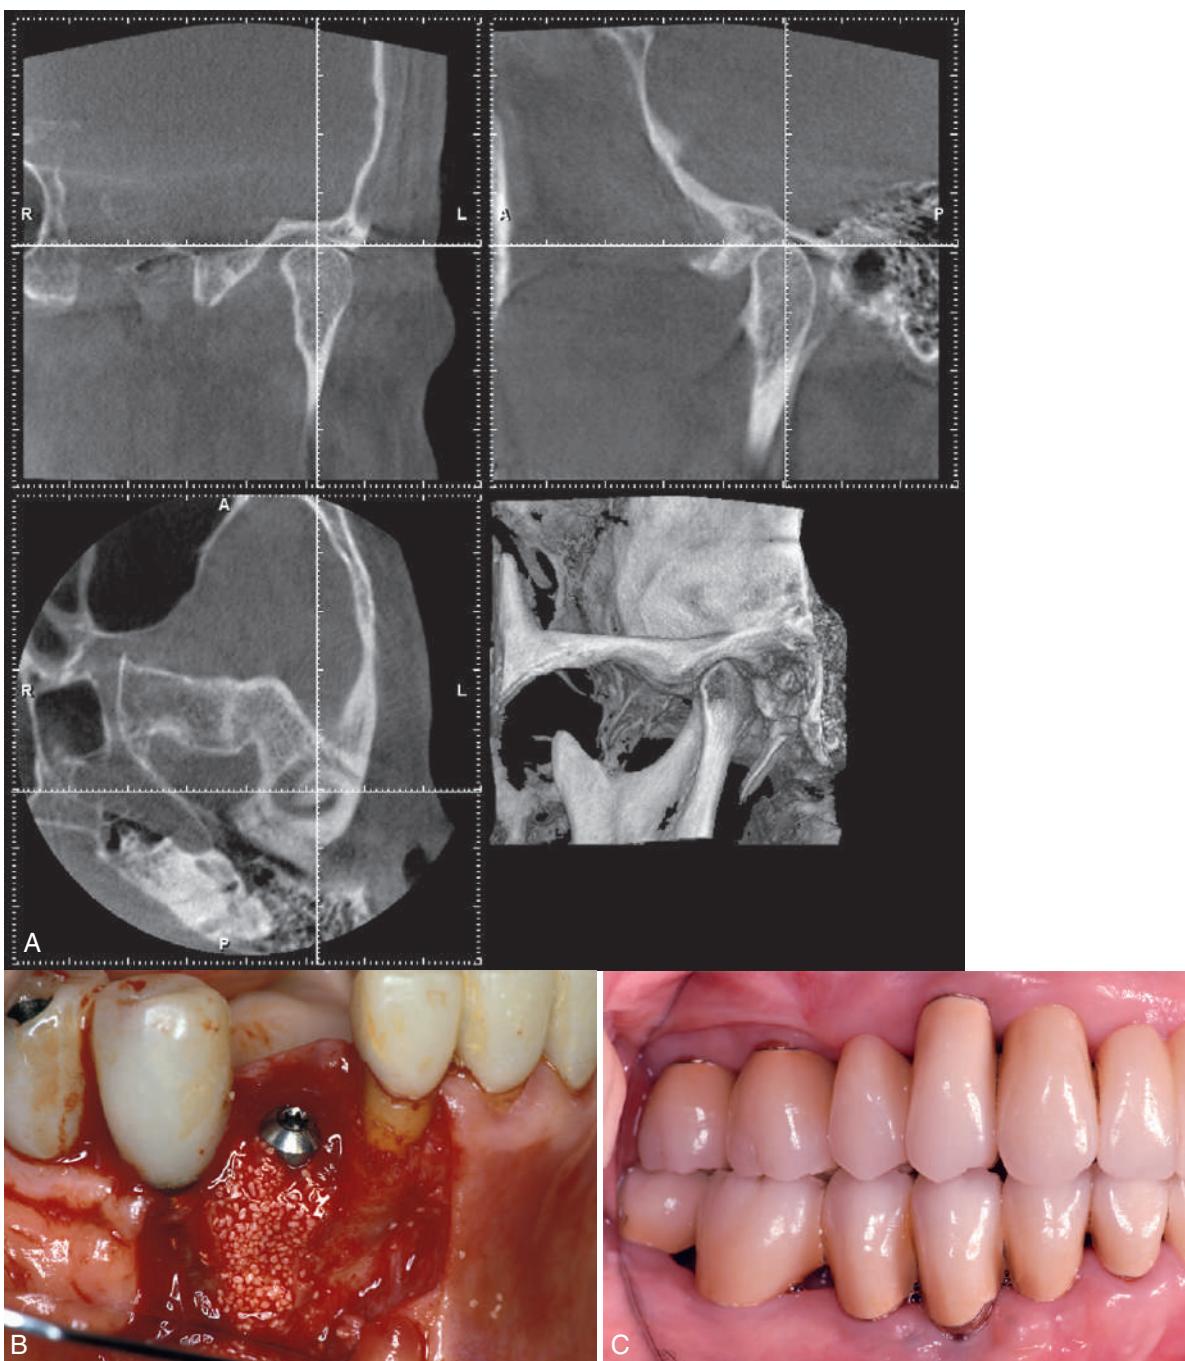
(A) Cone beam technology is useful for definitive evaluation of pathologic conditions of the temporomandibular joint because it enables viewing of any desired cross section. (B) Ridge augmentation surgery. (C) Completed restoration.
